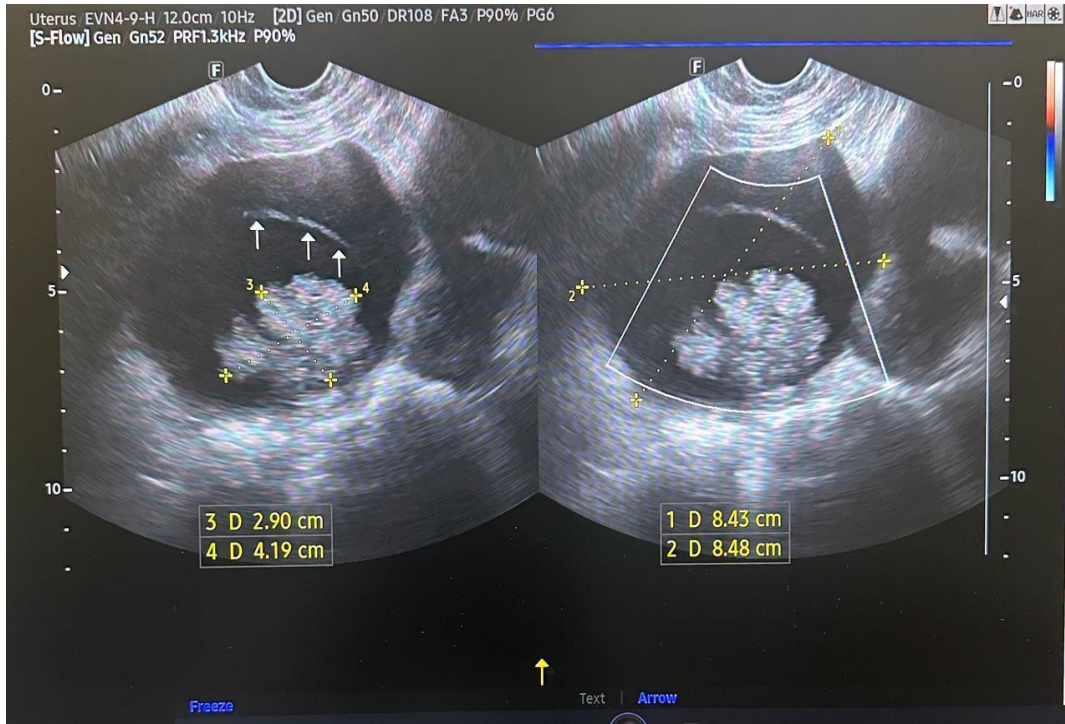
Transvaginal ultrasound image for a 39-year-old married who presented with pelvis pain show Lt ovarain masses measure (8.48 x 8.43cm) with internal soft tissue (4.19 x2.90cm) and septation. Ovarian cystadenocarcinoma
